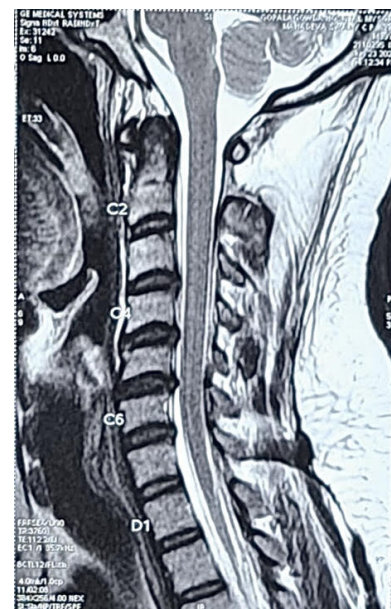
Normal spinal MRI.
